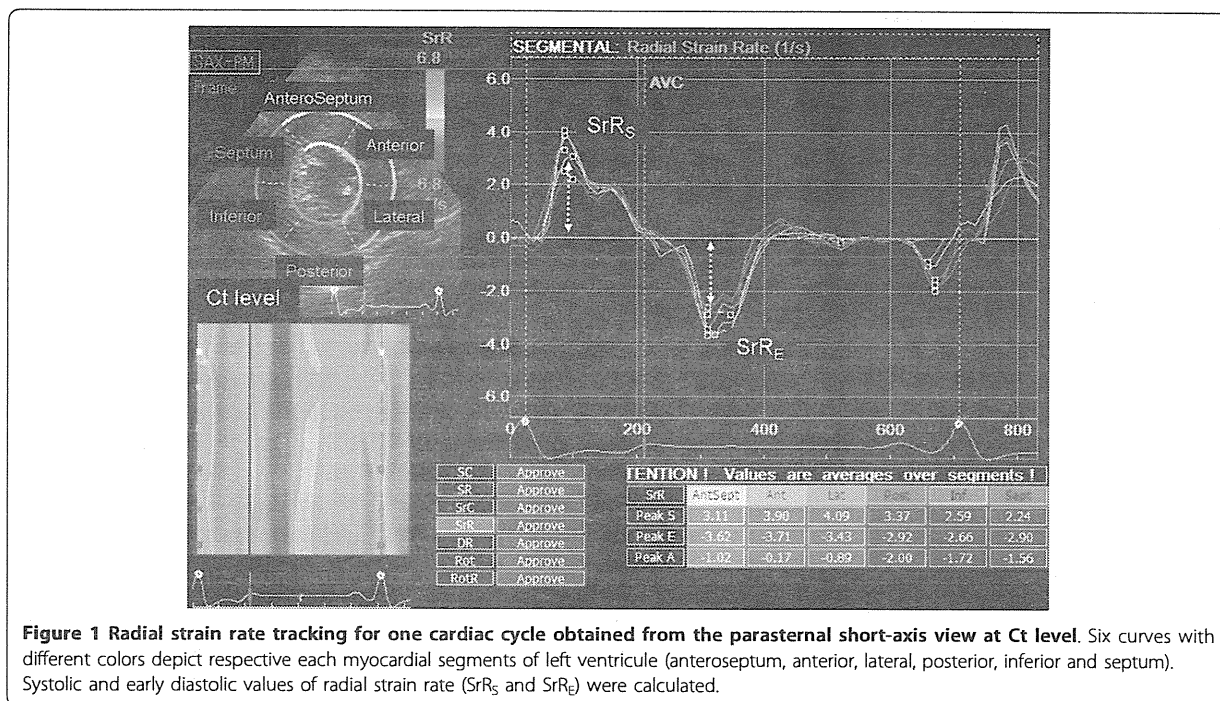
Radial strain rate tracking for one cardiac cycle obtained from the parasternal short-axis view at Ct level. Six curves with different colors depict respective each myocardial segments of left ventricle (anteroseptum, anterior, lateral, posterior, inferior and septum). Systolic and early diastolic values of radial strain rate (SrR_S and SrR_E) were calculated.
